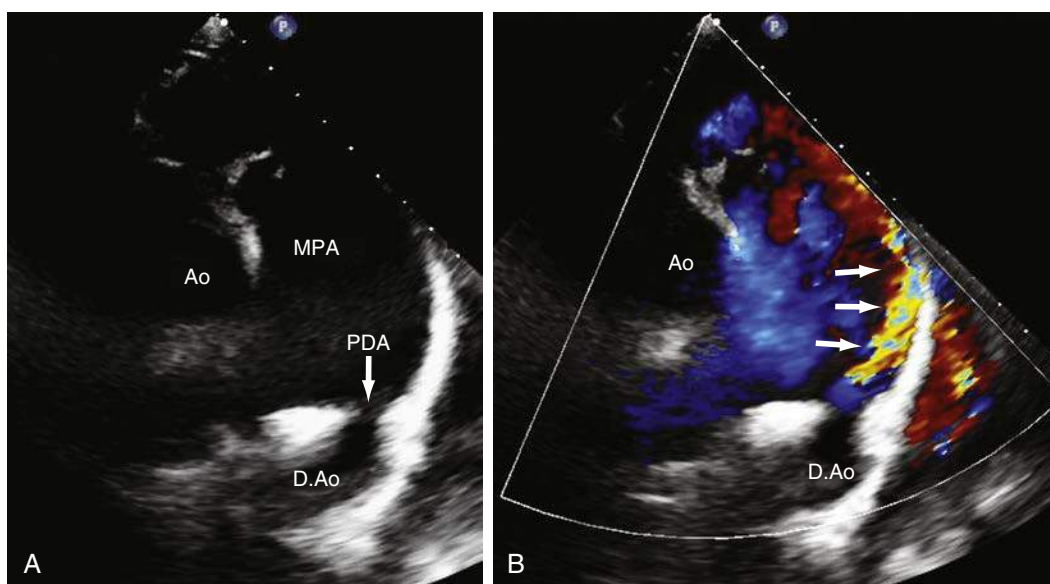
A, Two-dimensional transthoracic echocardiography (2D TTE) from the parasternal short-axis view showing a PDA (white arrow). B, Color Doppler shows left-to-right shunt through the PDA (white arrows). Ao, aorta; D.Ao, descending aorta; MPA, main pulmonary artery; PDA, patent ductus arteriosus.
